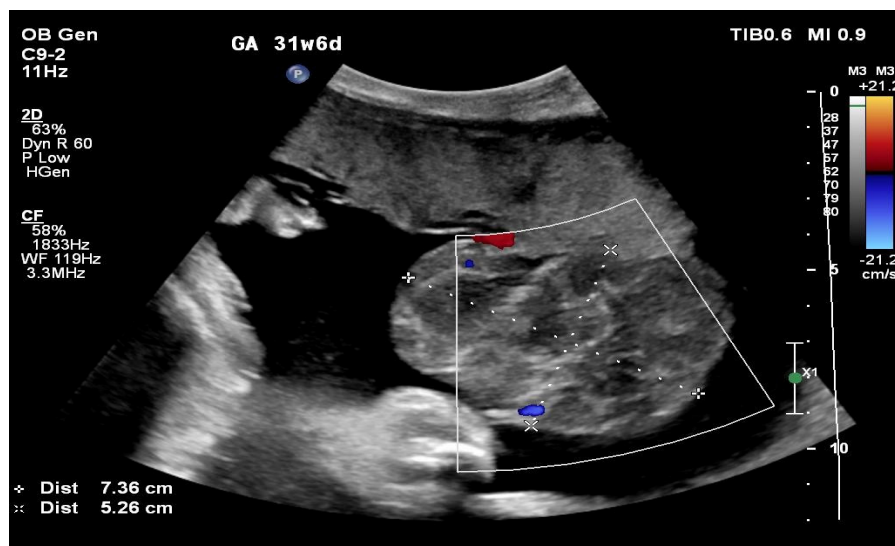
A gray scale ultrasound image shows the protruding placental mass into the amniotic cavity from a placenta with a 5.26 cm diameter.
